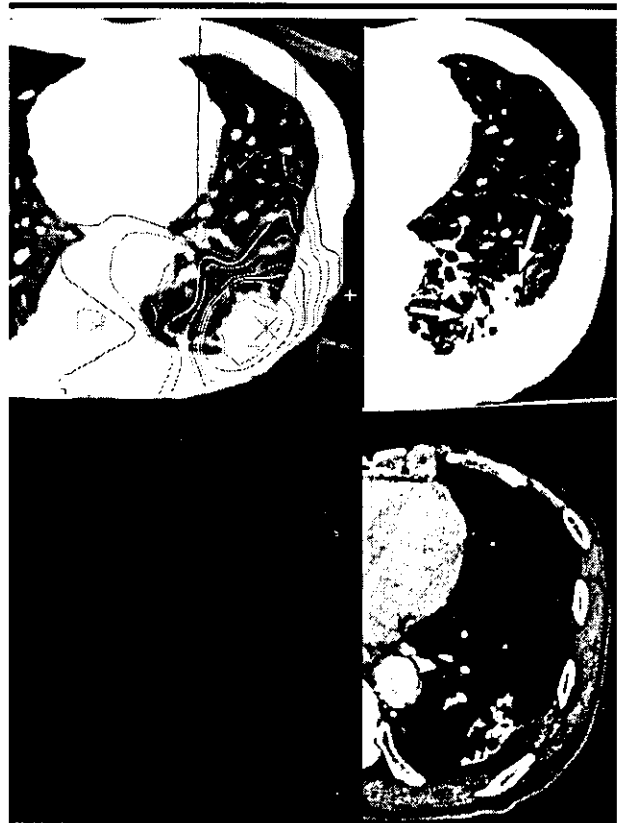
Transverse CT images show a representative case of discrete consolidation. Left: Image obtained for treatment planning at the isocenter. Right and bottom: Images obtained 10 months after SRT. Consolidation (arrows) involving the high-dose area (≥ 24 Gy) (not strictly conforming to the 24 Gy isodose line) in the treatment-planning CT image was observed with the lung window setting (top right) and could be partially detected with the soft-tissue window setting (bottom).
